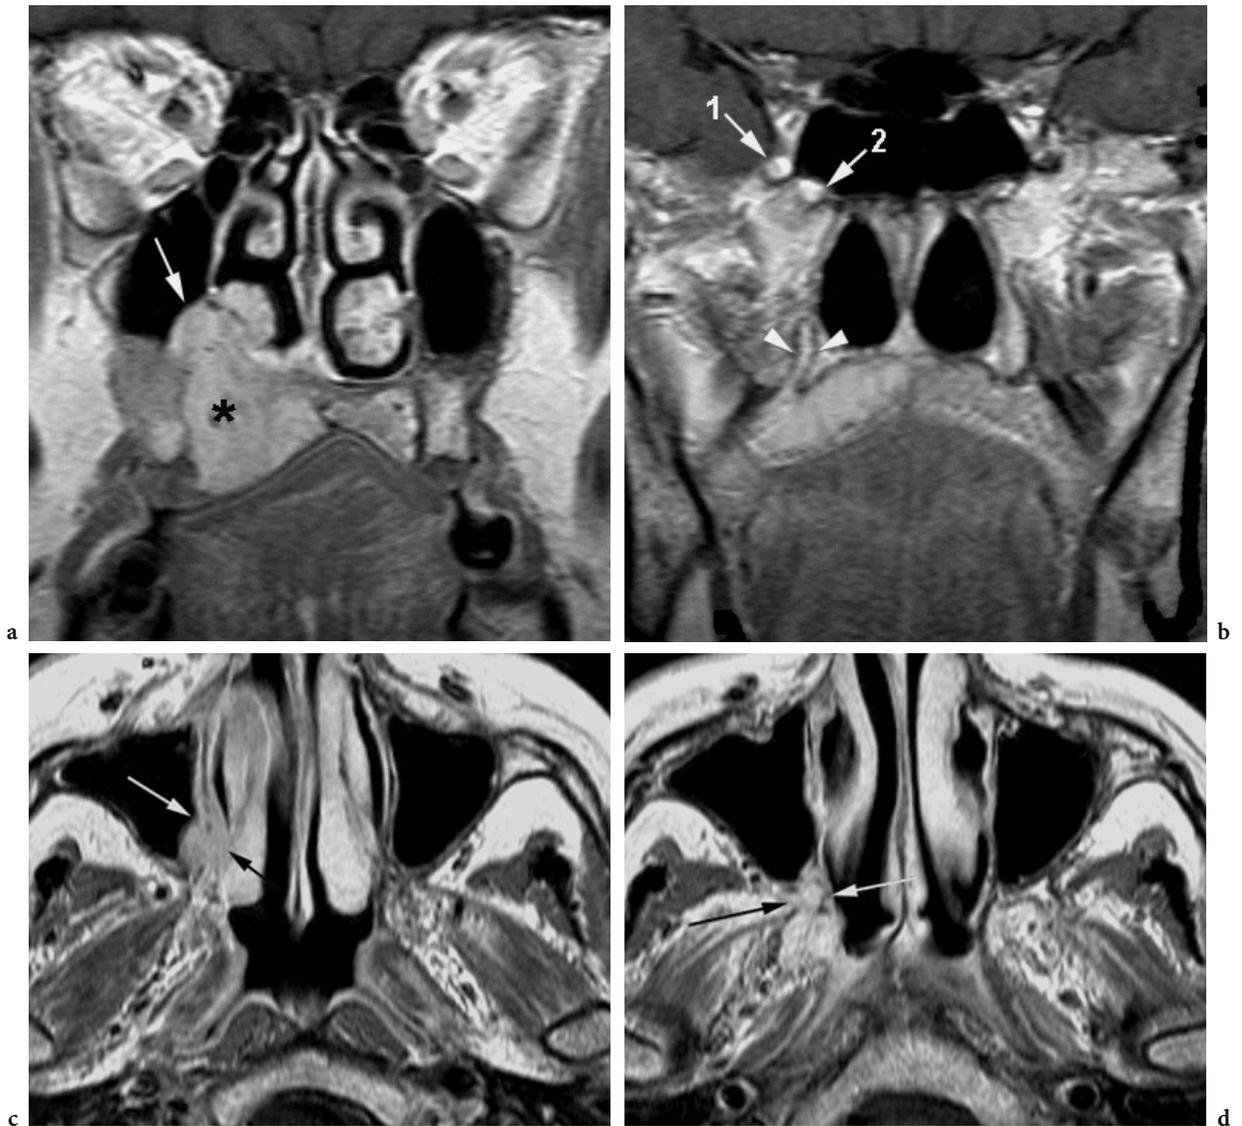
Adenoid cystic carcinoma with perineural spread Contrast enhanced T1-weighted coronal (a–b) and axial (c–d) planes. a The neoplasm (*asterisk*) arise from the right hard palate, abutting the alveolar recess of maxillary sinus (*arrow*). b Perineural spread is detected along palatine nerves (*arrowheads*) and more centrifugally along both the maxillary nerve (*1*) and vidian nerve (*2*). c Submucosal tumor growth is shown along both surfaces of medial antral wall (*arrows*) reaching posteriorly the pterygopalatine fossa. d Solid and enhancing tissue fills the widened pterygopalatine fossa (*arrows*)
